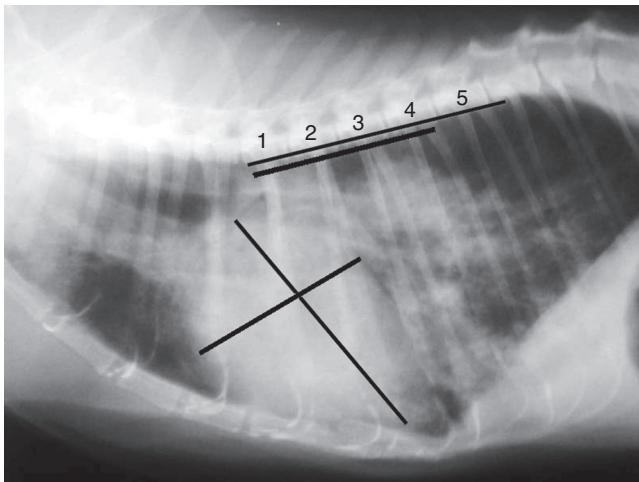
Measurement of vertebral heart scale on the lateral radiographic view. The same method is used as for the dorsoventral view. In this example the vertebral heart scale measures 9 vertebrae. Note the marked interstitial–alveolar pattern in the caudal and accessory lung lobes, consistent with congestive heart failure (pulmonary edema).
